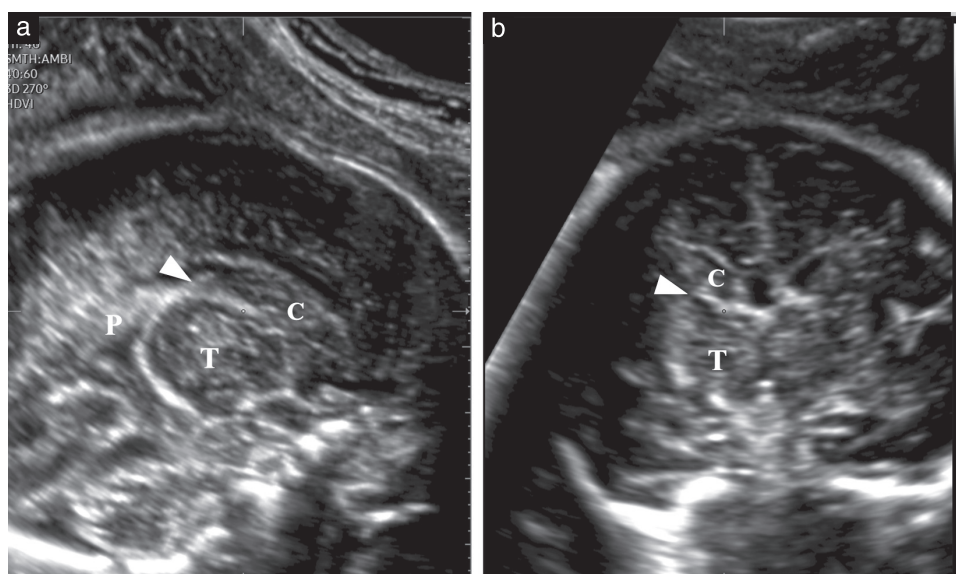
Three-dimensional transabdominal ultrasound images in normal fetus at 28 weeks' gestation, showing caudothalamic groove (arrowhead) in parasagittal (a) and coronal (b) planes. Choroid plexus (P) is also visible in (a). C, nucleus caudatus; T, thalamus.
